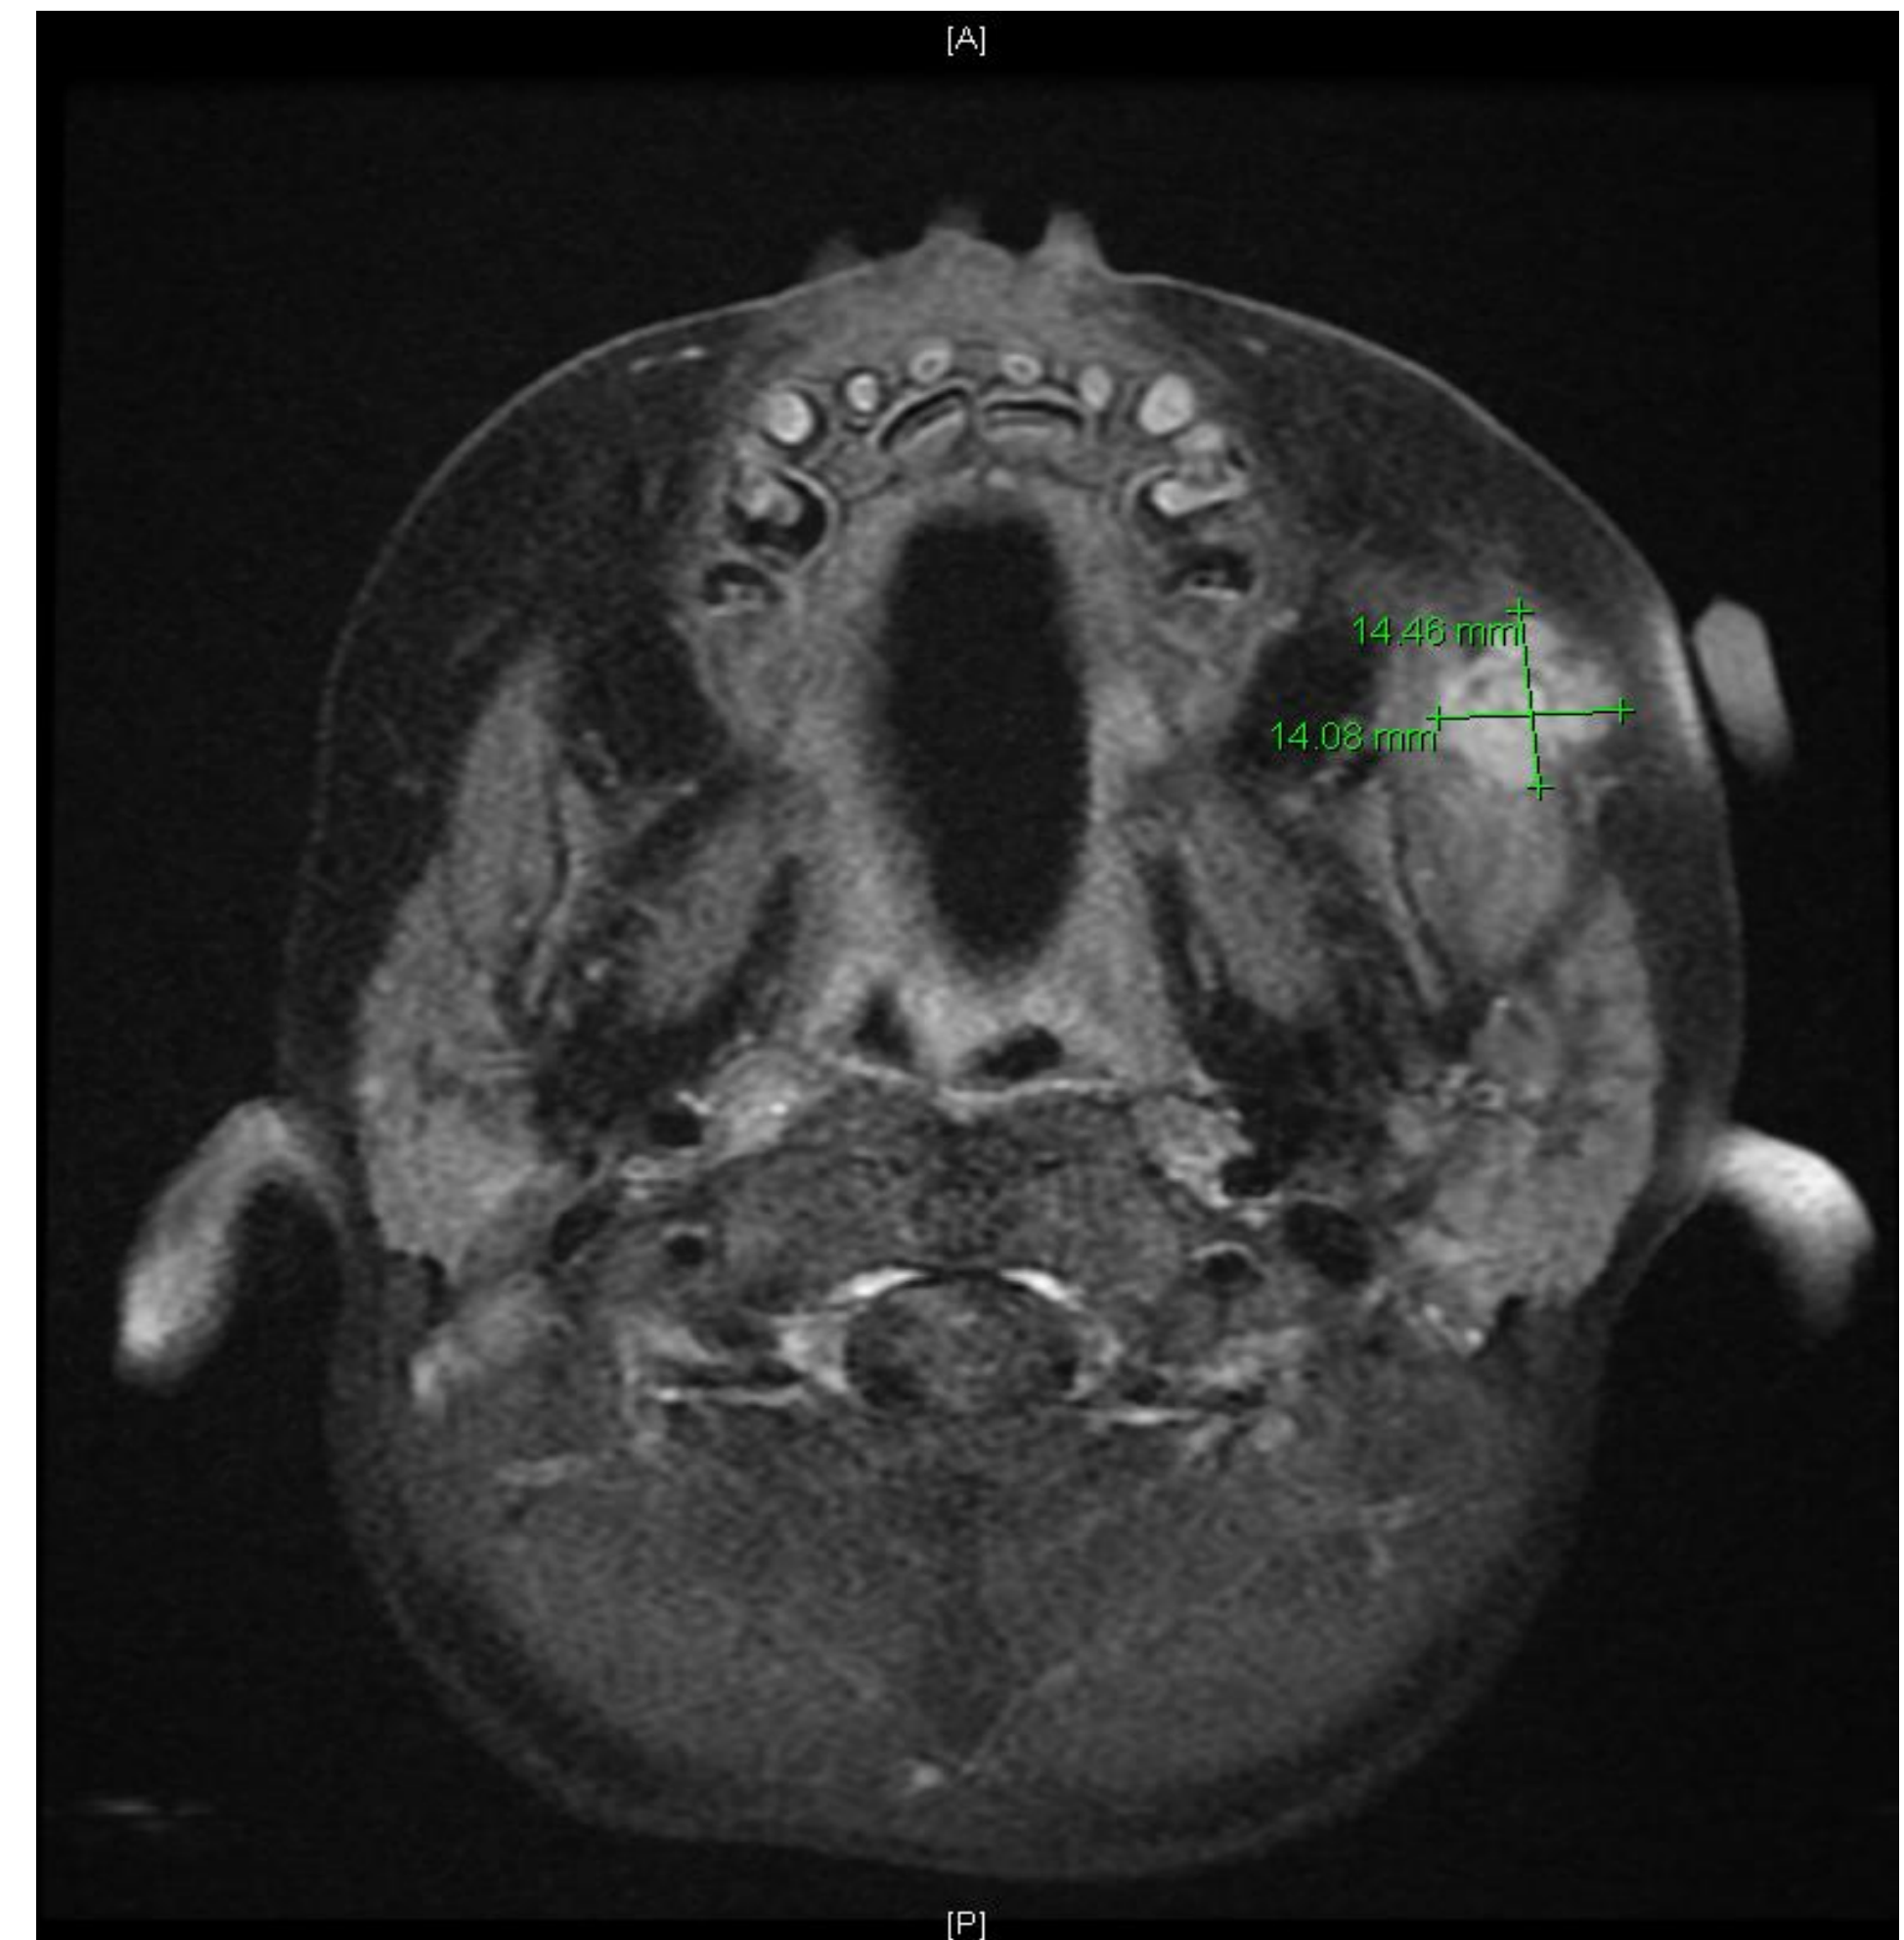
T2-weighted MRI revealed a homogeneously enhancing 16 mm x 13 mm x 11 mm mass with indistinct margins centered within the left masseter muscle and protruding into the subcutaneous tissues laterally.
